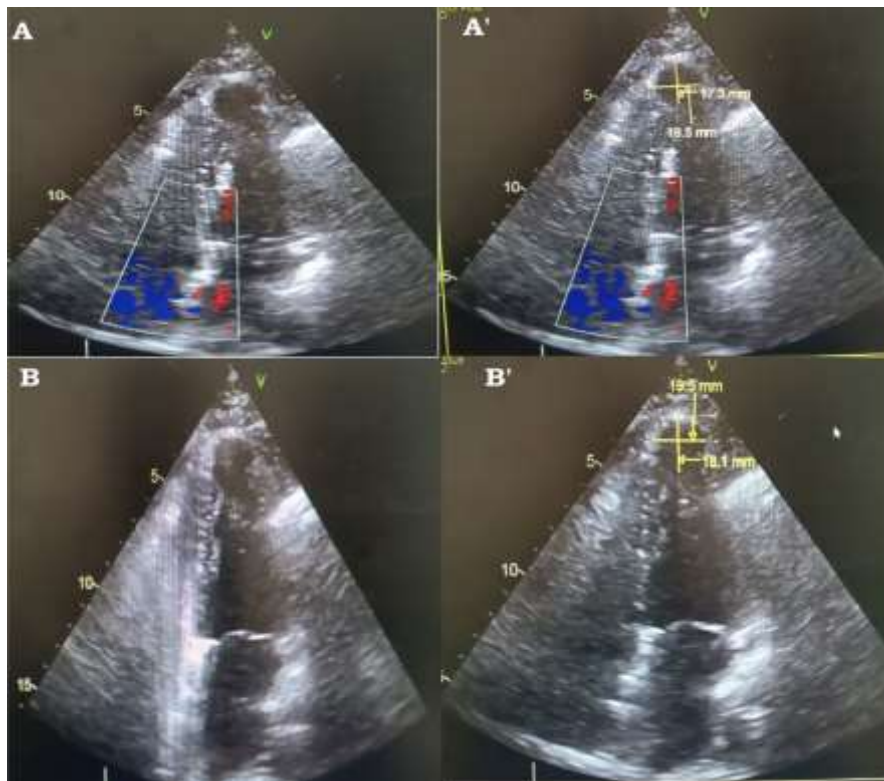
Contrast echocardiography showing apical aneurysm aspect of the left ventricle measuring 17.3mm*19.5mm in apical four chamber (A') and 19.5mm*18.1mm in apical two chamber (B').
